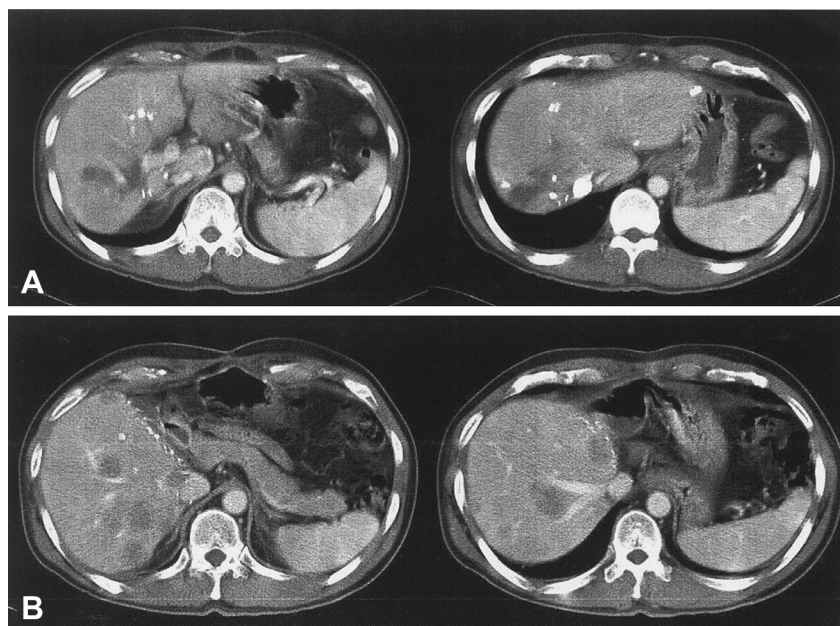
Critical case of hepatocellular carcinoma (HCC) recurrence after living-donor liver transplantation for advanced HCC close to the inferior vena cava (IVC) wall and the hepatic vein (HV) confluence. (A) Preoperative computerized tomography (CT) scan showing multiple hepatocellular carcinomas close to the IVC wall and HV confluence. (B) Follow-up CT scan 12 months after transplantation revealed recurrence in the transplanted liver and IVC wall.
